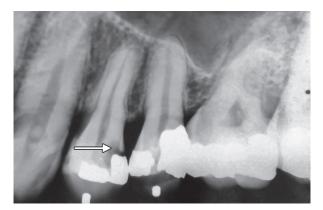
Radiograph showing secondary caries in the first premolar
